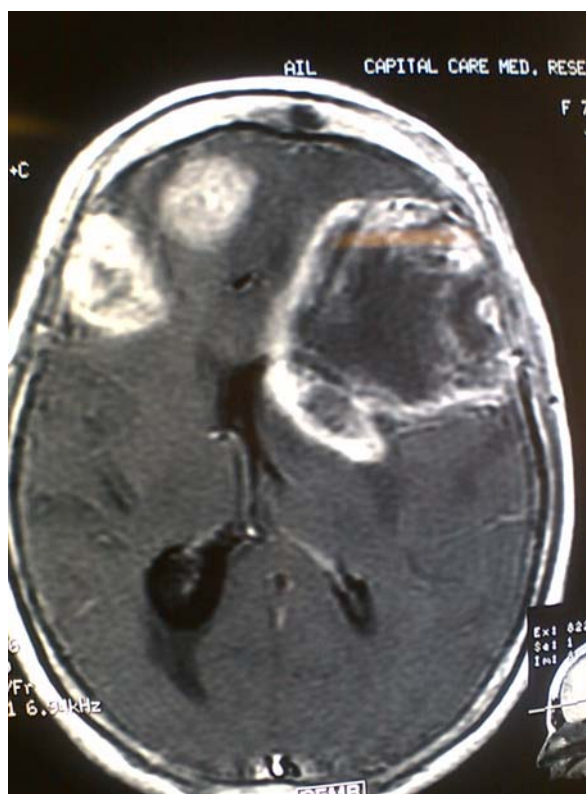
T1WI Axial MRI Brain of a Kashmiri orchard-farm worker showing Multicentric Glioma..
